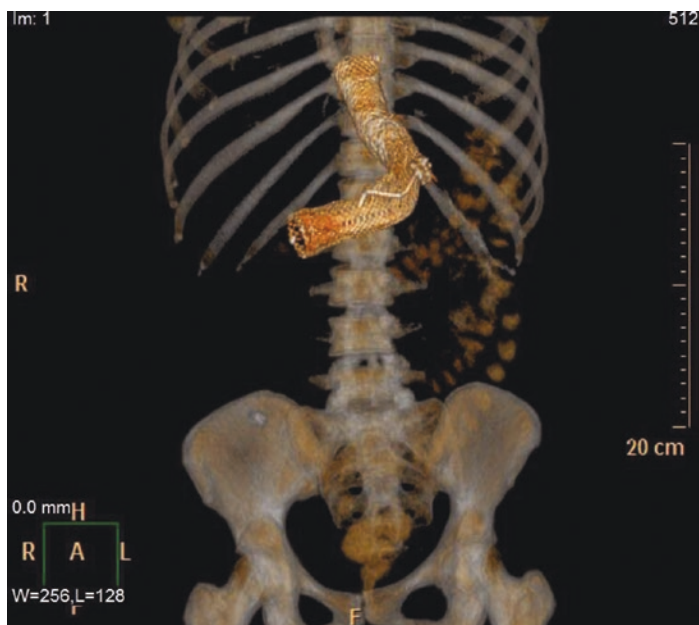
Mega stent in CT 3D view
